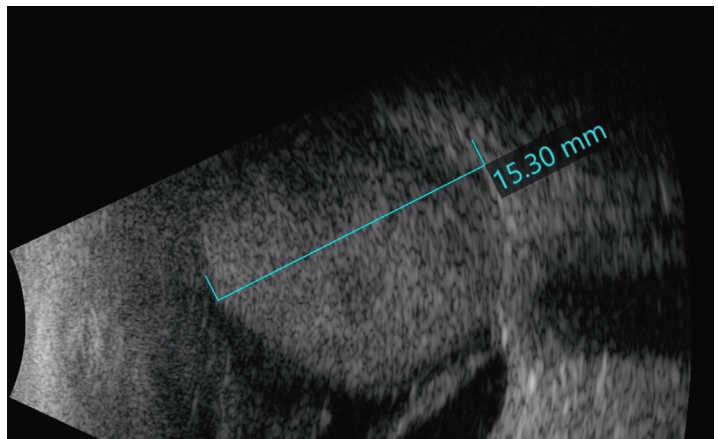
B-scan ultrasonography of the right eye showing an elevated choroidal mass with central cavitation and with retinal detachment inferiorly.
